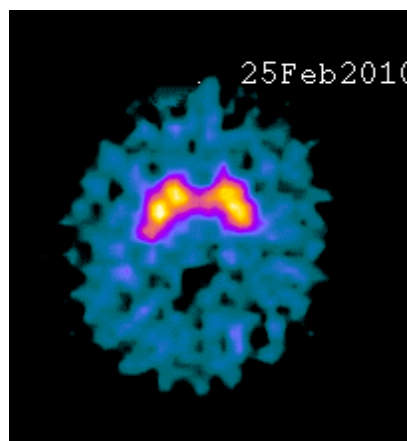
Normal ¹²³I-FP-CIT SPECT in patient with essential tremor
